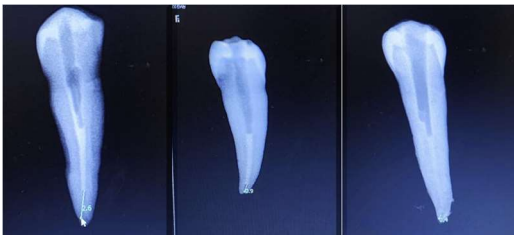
Dye Penetration Seen In Rvg Using MDA, Sonic , Ultrasonic Passive Irrigation, A. MDA B. Sonic Passive Irrigation C. Ultrasonic Passive Irrigation
